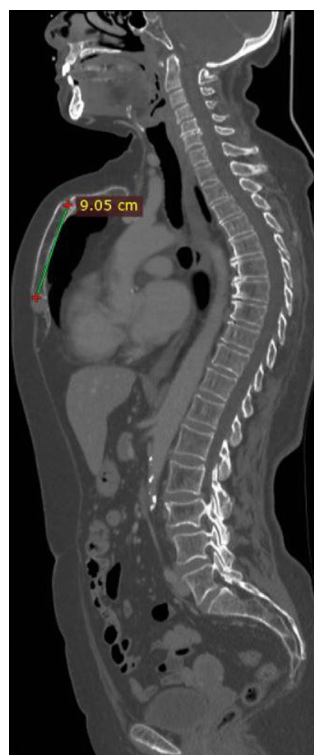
Sagittal whole body computed tomography scan showing a sternum body length of 9 cm and dorsal kyphosis.
